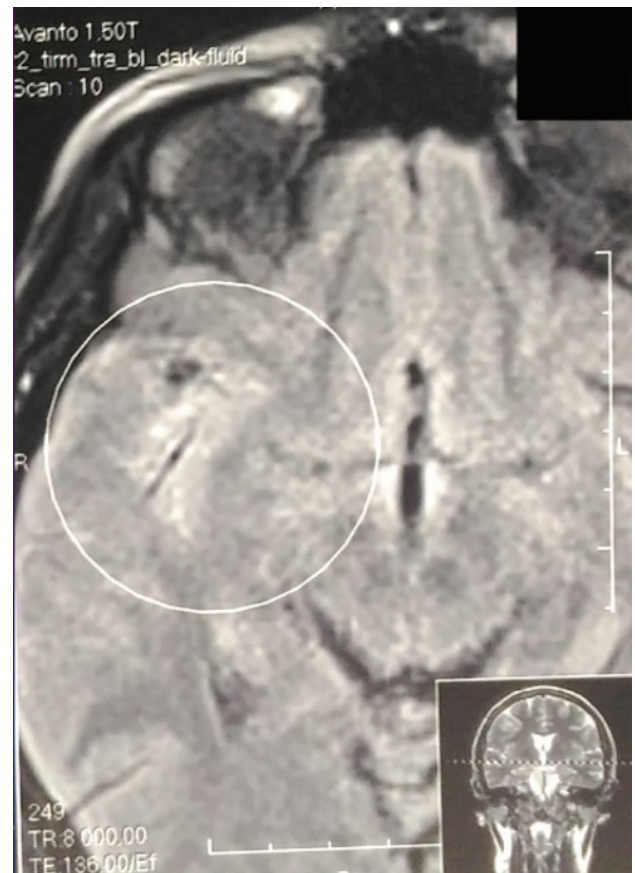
T2 weighted images of MRI brain showing areas of mild increased signal in right parietal lobe (made soon after admission).
